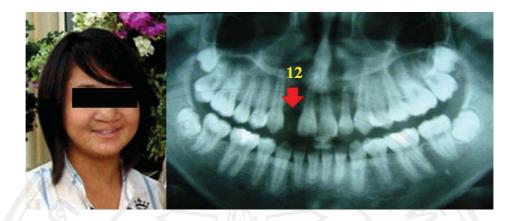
Clinical and radiographic findings of proband II. Clinical features include unilateral right cleft lip and palate. The panoramic radiograph shows hypodontia of tooth 12. Teeth 35 and 45 were extracted for orthodontic reason.
